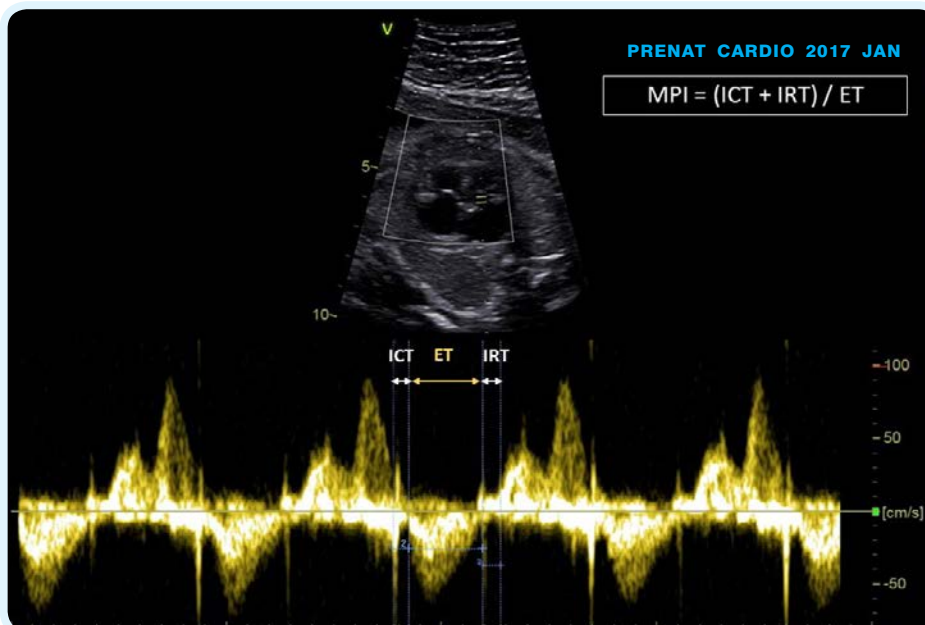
Myocardial performance index (MPI) using pulsed-wave Doppler.
